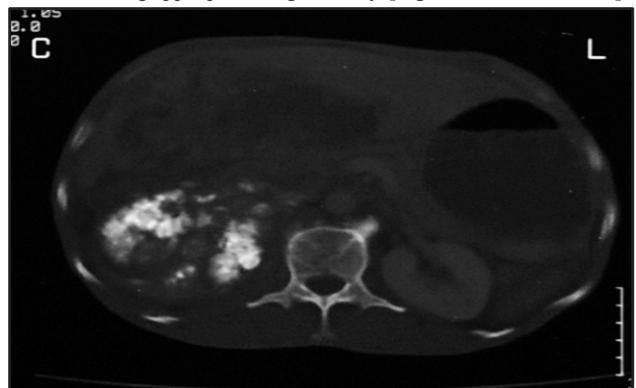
Axial CT image in bone window shows dense calcification/ossification within right renal mass lesion.
